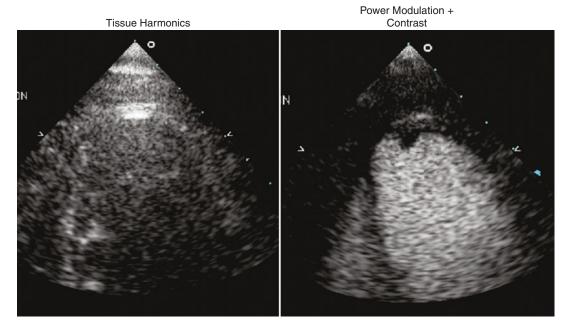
Zoomed apical 4 chamber views in a patient who had had an anterior infarct and a conventional echocardiogram (left) suggestive of a large apical thrombus. A contrast study using Power Modulation demonstrates that
